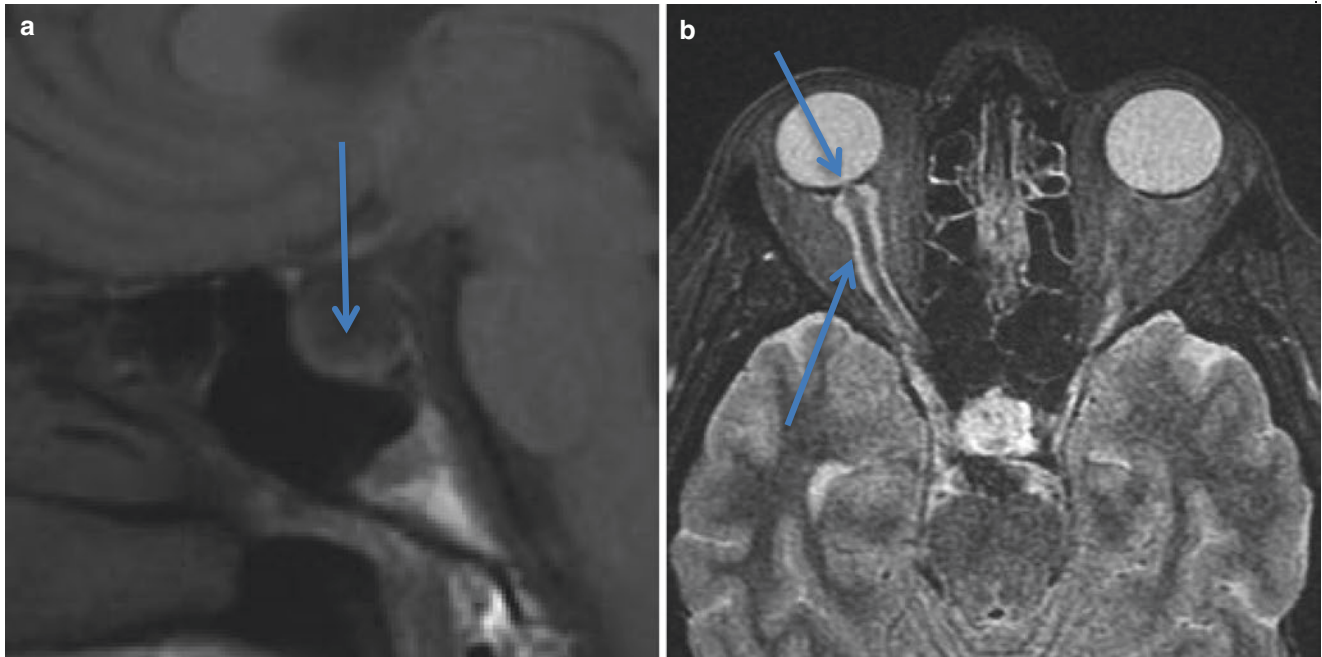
Empty sella turcica. (a) Sagittal T1-weighted image showing an enlarged sella turcica filled with cerebrospinal fluid (CSF). The pituitary gland is flattened (*arrow*) against the floor. (b) A female patient with idiopathic intracranial hypertension. Besides the empty
